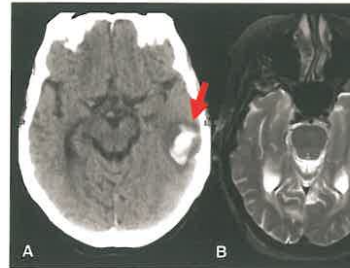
Amyloid Versus Hypertensive Microhematoma (red arrows) which blooms darker on old hemorrhages (aka “microbleeds”) on T2*, diffuse hemorrhage (T2, D, and T2*, E) more typical often keeping company with lacunes. Although CT weighted sequences are required to detect older m
